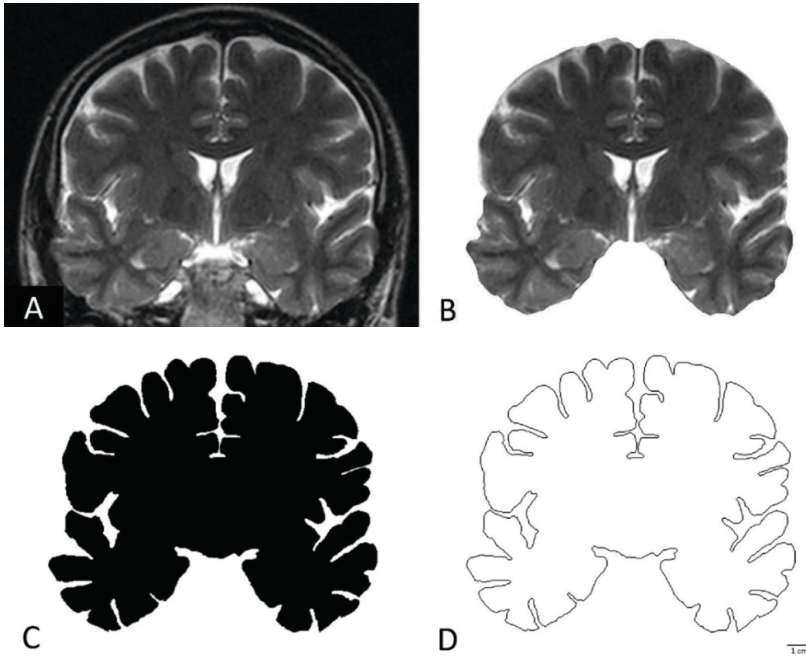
Pre-processing of MR brain images. A – MR image of cerebral hemispheres (Coronal 2, level of mammillary bodies); B – non-segmented tomographic section after background removal; C – segmented silhouette image; D – outlined image displaying the outer linear contour of cerebral hemispheres' pial surface. Scale bar = 1 cm.
